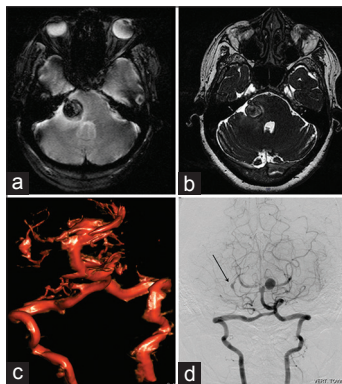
(a and b) MRI of a patient with trigeminal neuralgia, a T2 hypointense lesion is seen in the right cerebellopontine angle, the susceptibility weighted imaging shows evidence of blood (c) Computerized tomography angiogram shows a partially thrombosed distal right SCA aneurysm with a left sided PCA aneurysm. (d) Digital subtraction angiography shows only partial filling right SCA aneurysm, the left PCA aneurysm appears to be fusiform involving the main vessel. The SCA aneurysm was trapped using a retromastoid approach; the PCA aneurysm was coiled later
